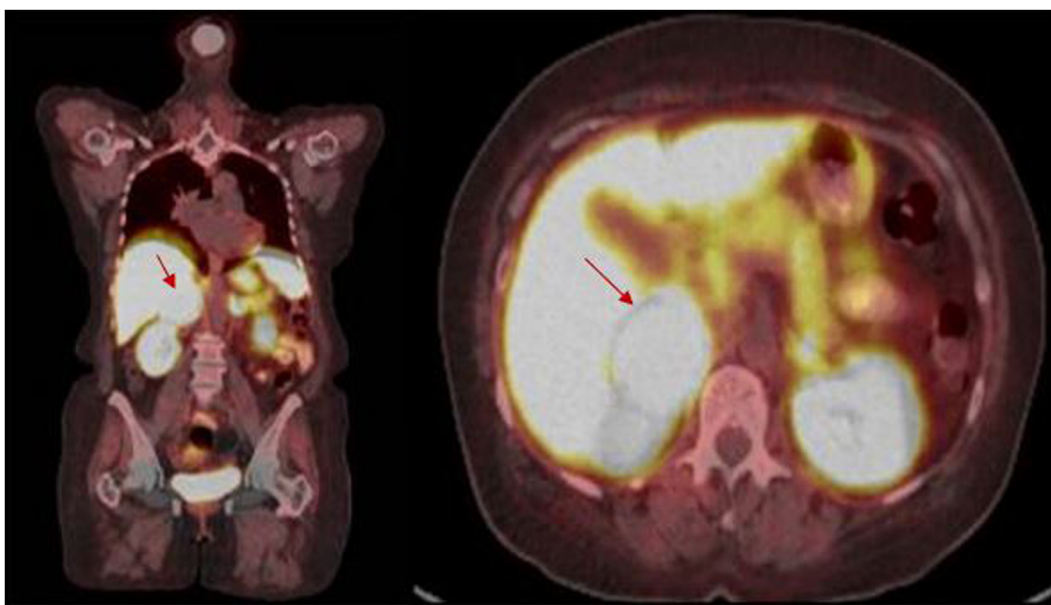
Gallium-68-DOTATATE positron emission tomography/computed tomography showing an avid right adrenal mass.
